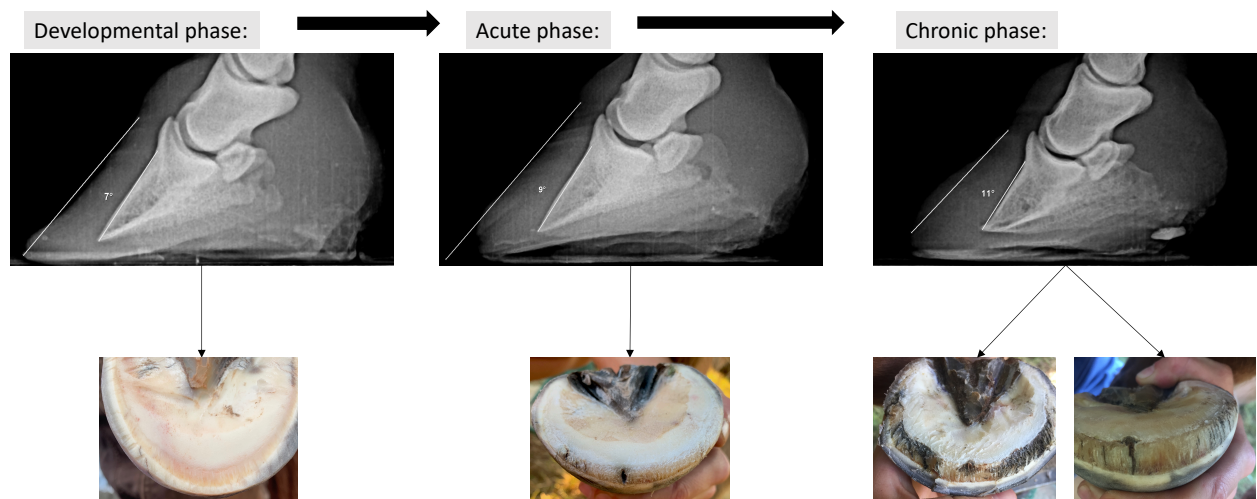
Radiographic images of rotation of the coffin bone with broadening of the white line, i.e. laminar tissue, during the 3 phases of laminitis.
